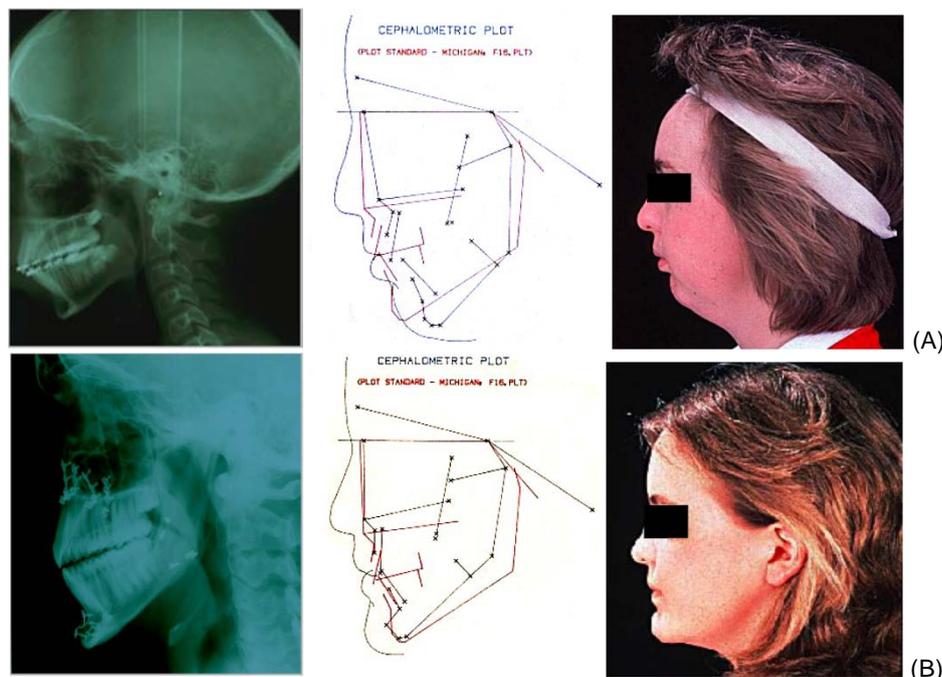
Radiographs, cephalograms and clinical photographs of pre (A) and post (B) genioplasty compared to assess degree of advancement and resorption.
